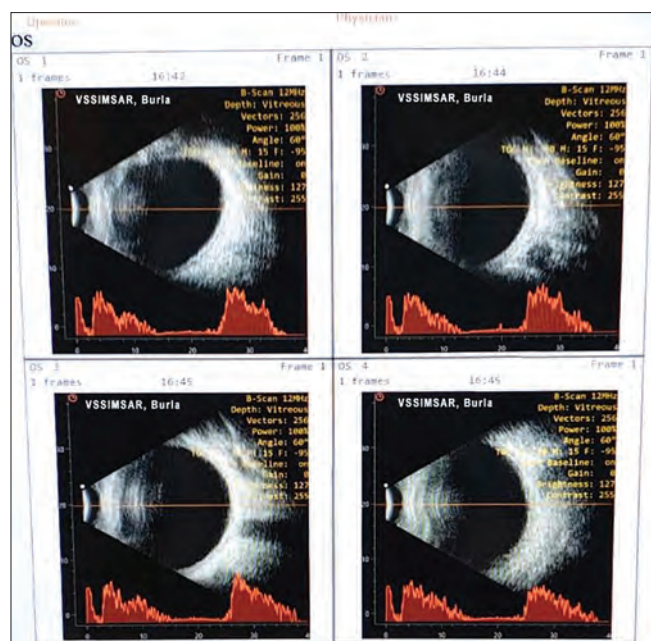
Ultrasonography B-scan done for the left eye showing normal posterior segment findings
